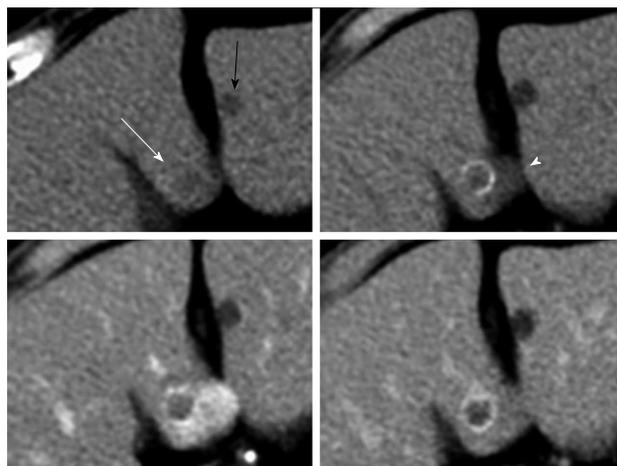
Findings of computed tomography. Upper left, plain abdominal computed tomography (CT) taken at the initial diagnosis revealed a 1-cm low-density lesion without calcification in liver segment 4 (white arrow). A small low-density area found in the left lateral section was a liver cyst (black arrow); upper right, plain abdominal CT taken 6 mo after the initial diagnosis revealed that the lesion had a ring calcification and an adjacent 1.8-cm lesion (white arrowhead); lower left and right, abdominal CT taken 6 mo after the initial diagnosis in the early phase (lower left) after a bolus administration of intravenous contrast material showed enhancement of the newly appeared lesion and the delayed phase (lower right) showed that it was hypoattenuated.
